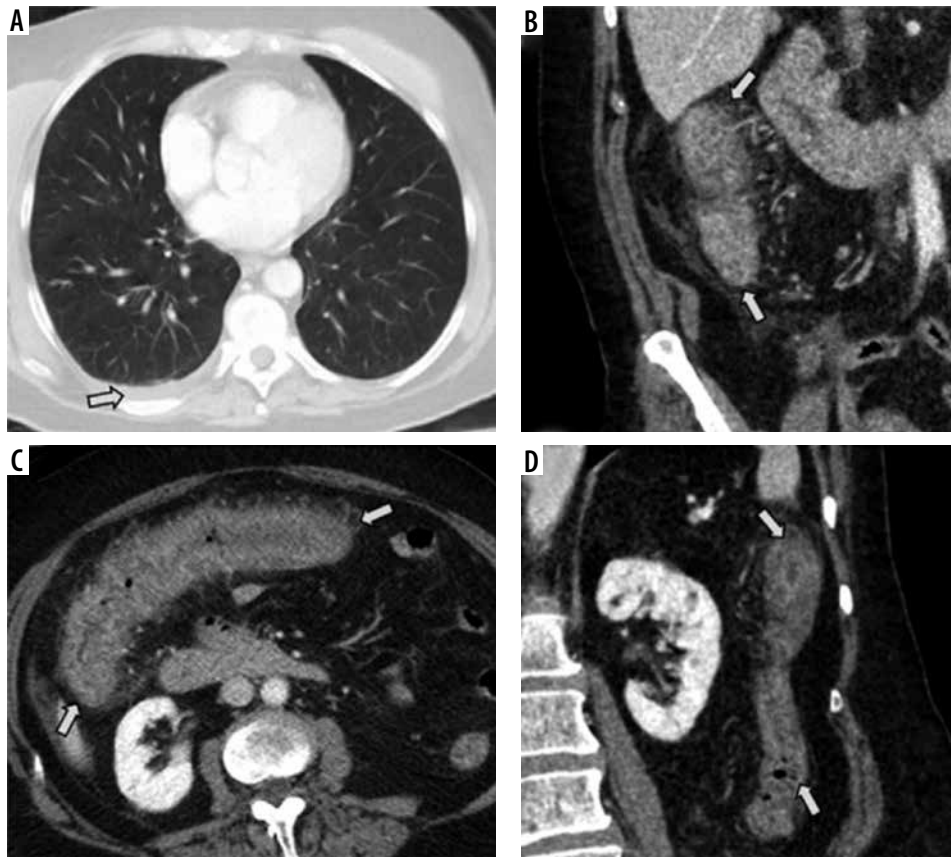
Initial computed tomography (CT) scan of the abdomen and pelvis of patients infected with SARS-CoV-2. A) Axial CT image of the lower thorax shows no airspace disease in the lungs. A small, right pleural effusion is present (arrow). B-D) Intravenous contrast-enhanced CT scan of the abdomen and pelvis in the coronal (B and D) and axial (C) planes shows severe inflammation of the ascending colon (B), transverse colon (C), and descending colon (D) characterized by circumferential wall thickening, mural hyperenhancement, mesenteric hypervascularity, and pericolic fat stranding (arrows)
